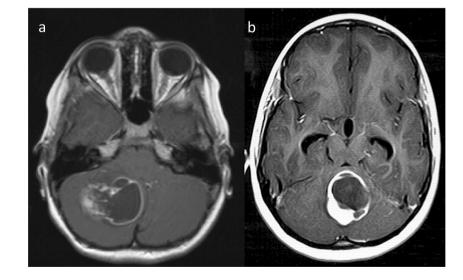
Cystic appearance of a cerebellar astrocytoma without a noticeable mural nodule on MRI with contrast
